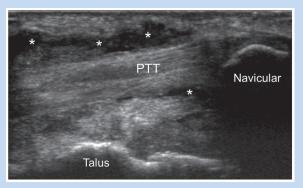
Sonographic assessment of the ankle in a patient with medial-sided pain. Ultrasound image demonstrates a thickened and hypoechoic distal posterior tibial tendon (PTT) surrounded by complex tendon sheath effusion (*), in keeping with tenosynovitis.
